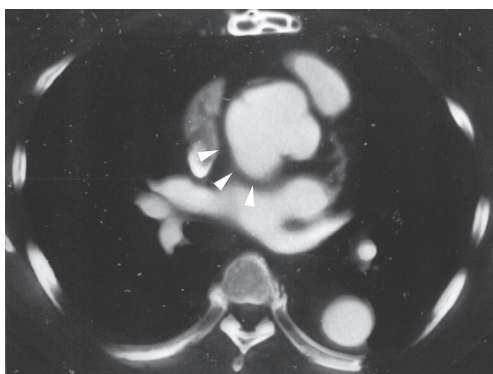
Computed tomography scan showing dissecting aneurysm change (arrow) of ascending aorta continuing from non-coronary cusp.
